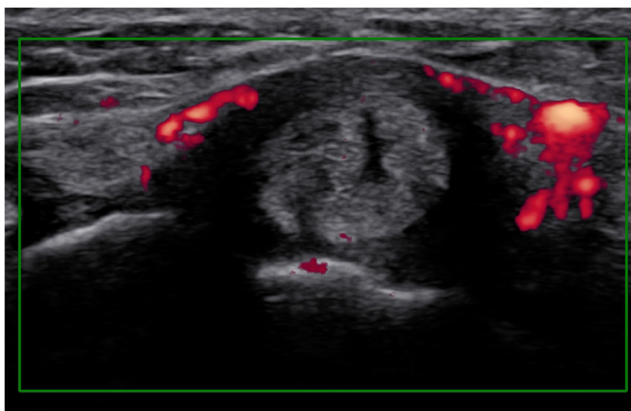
Ultrasound appearance of EDCST in the same patient as Fig. 1. Transverse power Doppler sonogram obtained over the ER shows its hypoechoic appearance associated with thickening and local hyperemia
